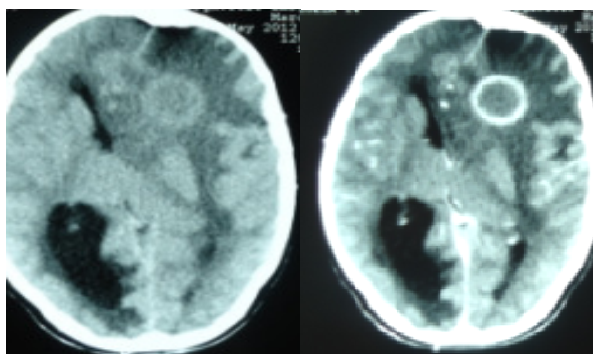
A 14 years male patient presented with visual loss of 1month duration. On pre-contrast CT (left axial image), there is iso-dense frontal mass with hyperdense margin, significant mass effect perilesional edema & obstructive hydrocephalus. Post contrast images (right image) showed smooth ring enhancement.
